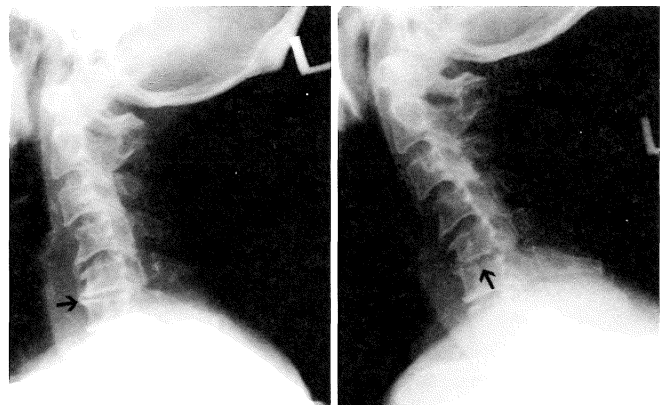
X-ray cervical spine. 3a. First admission (1.10.1996 on day 6 of neck pain): patchy bone loss in C5 vertebra and reduced C5/6 disc space (arrow).
